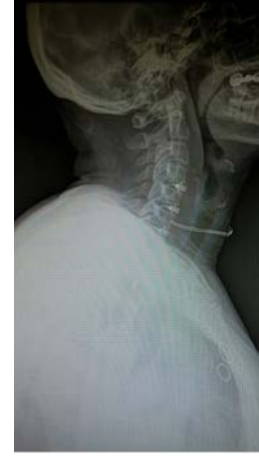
Postoperative lateral direct radiograph of C4-5, C5-6, and C6-7 bladed cage.
